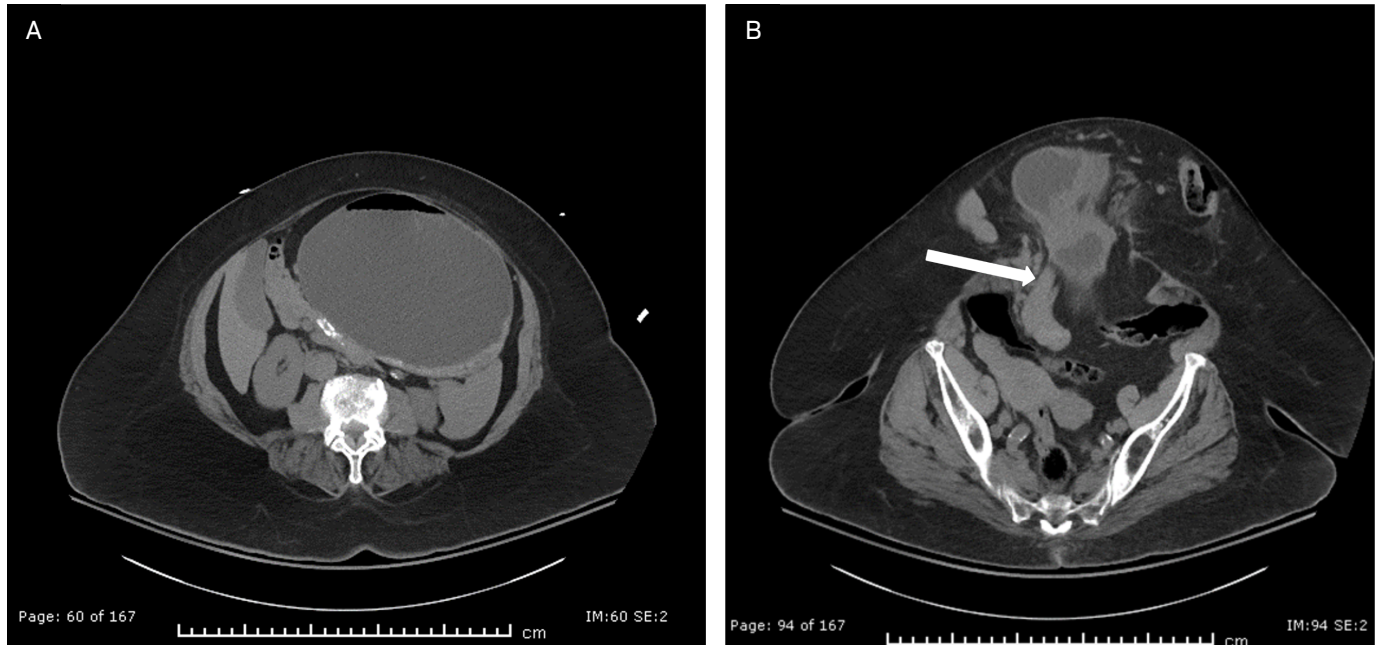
Additional contrast-enhanced abdomen and pelvis CT images acquired during the 1-month follow-up. (A) A more superior axial slice at the level of the kidneys demonstrating a fluid-distended stomach as a result of gastric outlet obstruction. (B) Axial slice at the level of the hernia neck showing herniation of the proximal duodenum (white arrow) and distal stomach with narrowing through the hernia neck.
